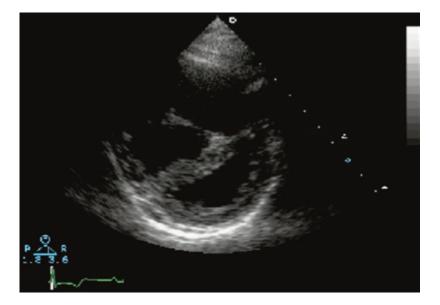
Transthoracic echocardiography (TTE), parasternal short-axis view of the right ventricle, and its volume measurement
